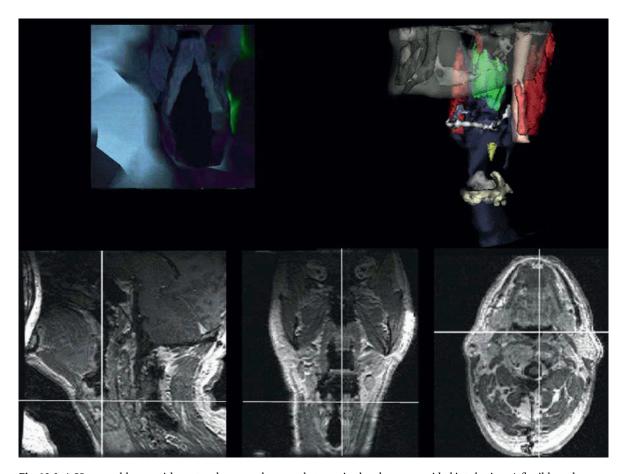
A 55-year-old man with a retropharyngeal tumor that required endoscopy-guided intubation. A flexible endoscope and miniature (1.2 mm diameter) electromagnetic sensor (Biosense, Seatauket, NY) were introduced together in an endotracheal tube. Multiple MR images, their three-dimensional (3D) rendering, and virtual endoscopy views were displayed during intubation, showing the progress of the endotracheal tube. MR images, 3D rendering, and virtual endoscopy images were registered to the patient before the procedure. *Upper left image*: virtual endoscopy image from the viewing point of the endoscope, showing the vocal cords. *Upper right image*: 3D rendering of head and neck region, showing the actual position of the endoscope's tip (*yellow arrowhead*). *Lower images*: multiplanar MR images displaying actual tip position (*crosshairs*). From: Jolesz FA et al. Am J Roentgenol 1997; 169:1229–1235. Permission granted
